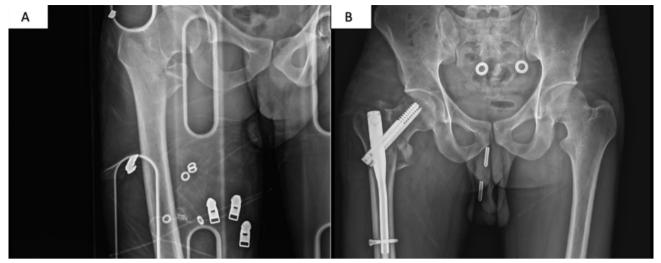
Radiological images of intertrochanteric hip fracture related to e-scooter accident. (a): Preoperative hip X-ray (b): Postoperative pelvis X-ray
